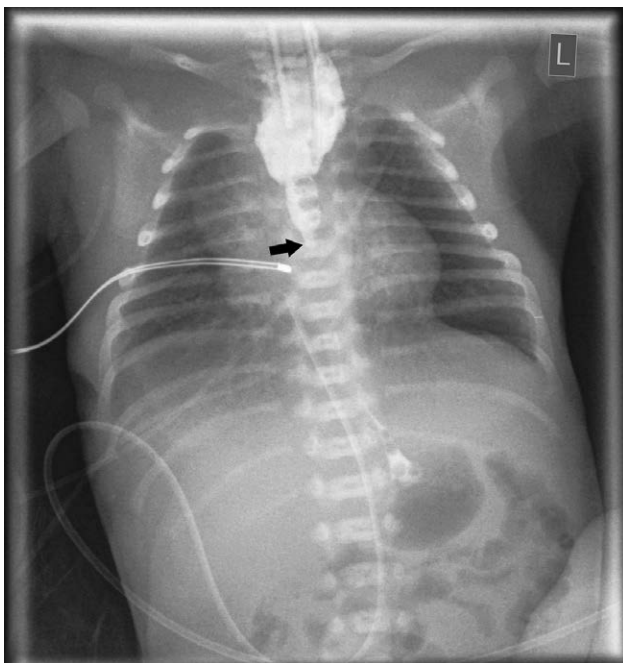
Chest radiograph showing the tip of a nasogastric tube (arrow) at the level of the tracheal bifurcation. A contrast agent was installed via this tube.
